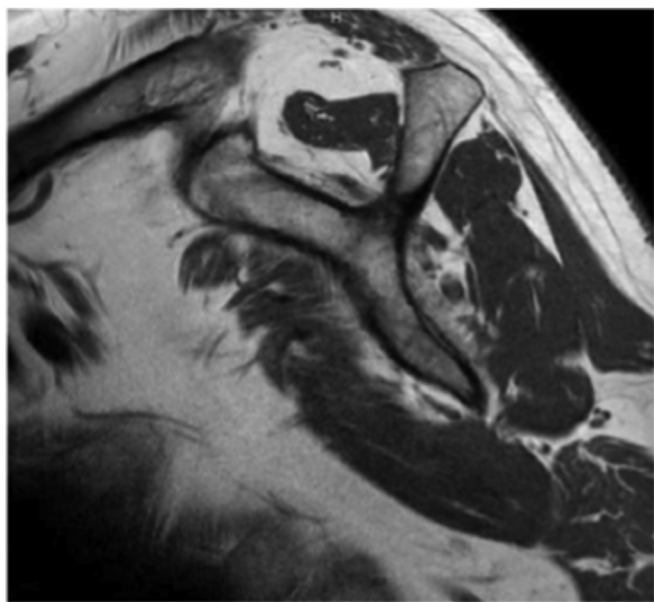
Sagittal T1 weighted magnetic resonance imaging demonstrating rotator cuff muscle atrophy.
